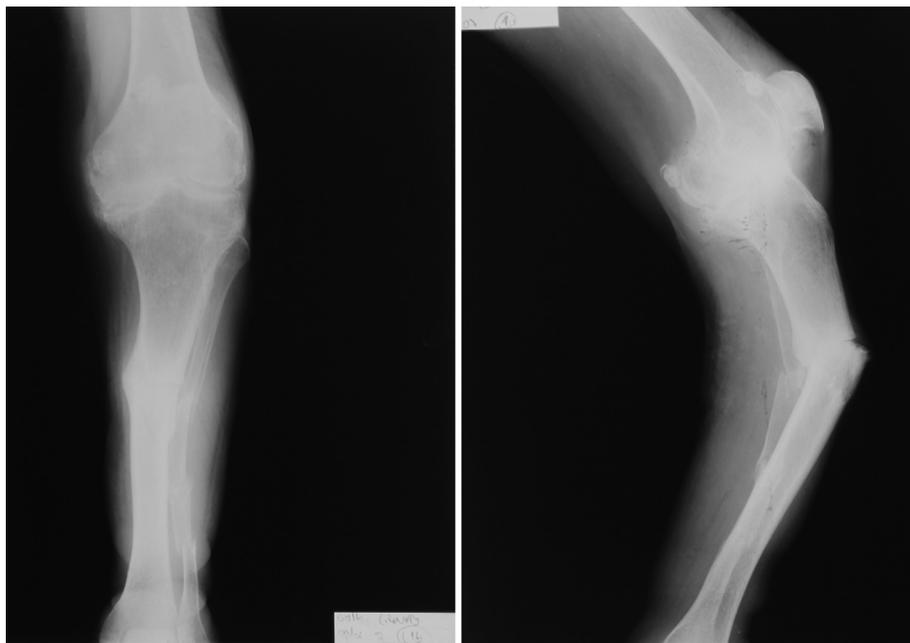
Preoperatively AP and lateral radiographs of the patient number 2.
